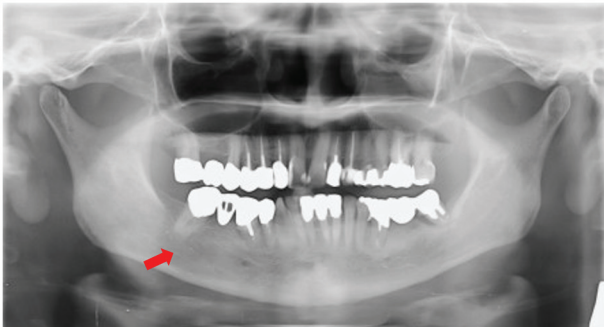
Orthopantomograph. The red arrow indicates mild resorption of the periapical alveolar bone extending from the right mandibular second premolar to the right mandibular second molar.
